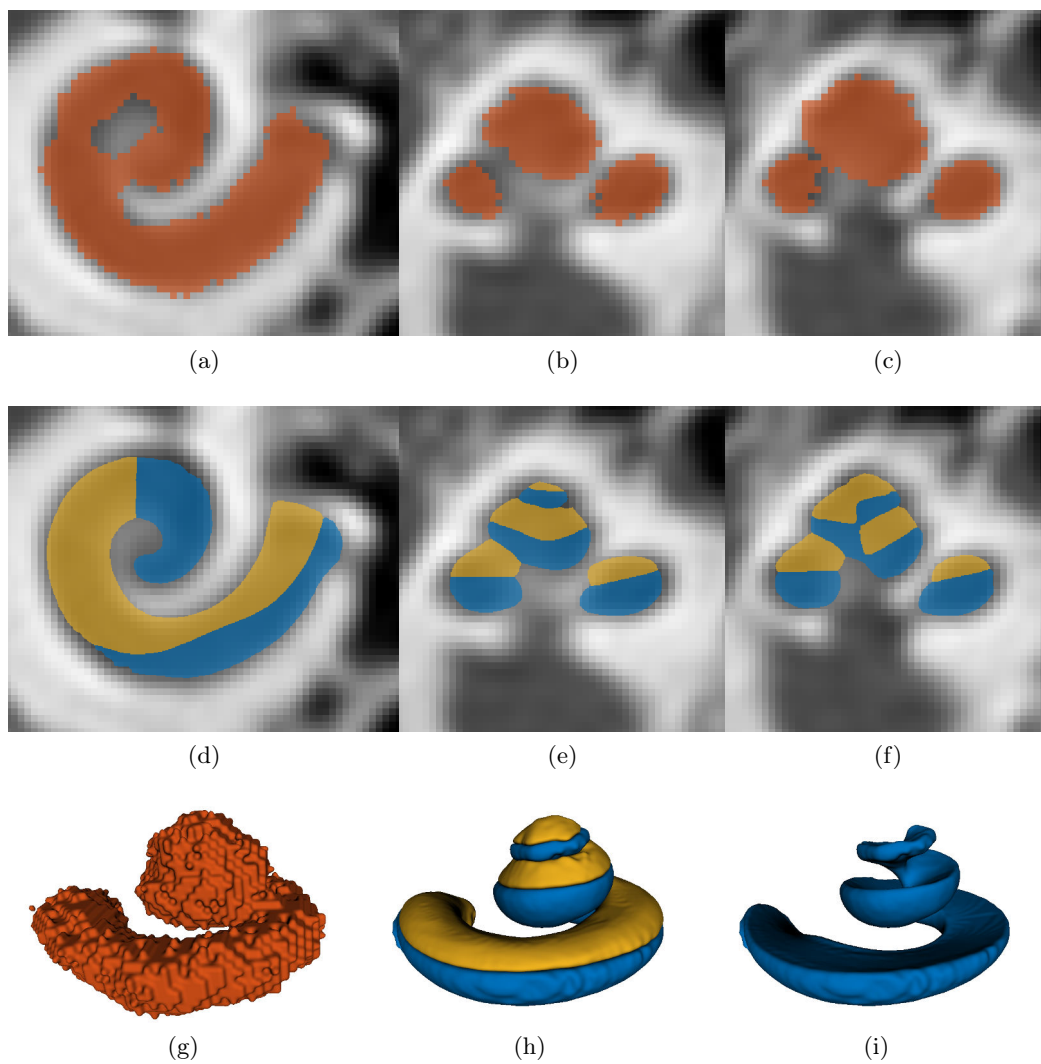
Comparison of the manual segmentation Z_0 (a), (b), (c) and (g) and the automatic segmentation \hat{Z} (d), (e), (f), (h) and (i) on CT images
